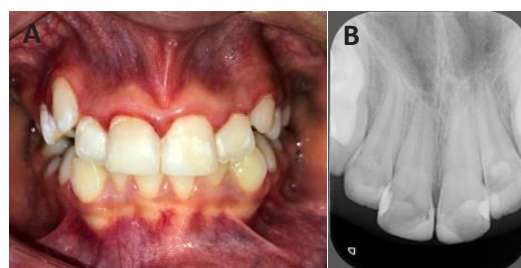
A) Clinical and B) radiological evidence of #11 and #21 of Case II indicate no periapical or pulpal pathology after
